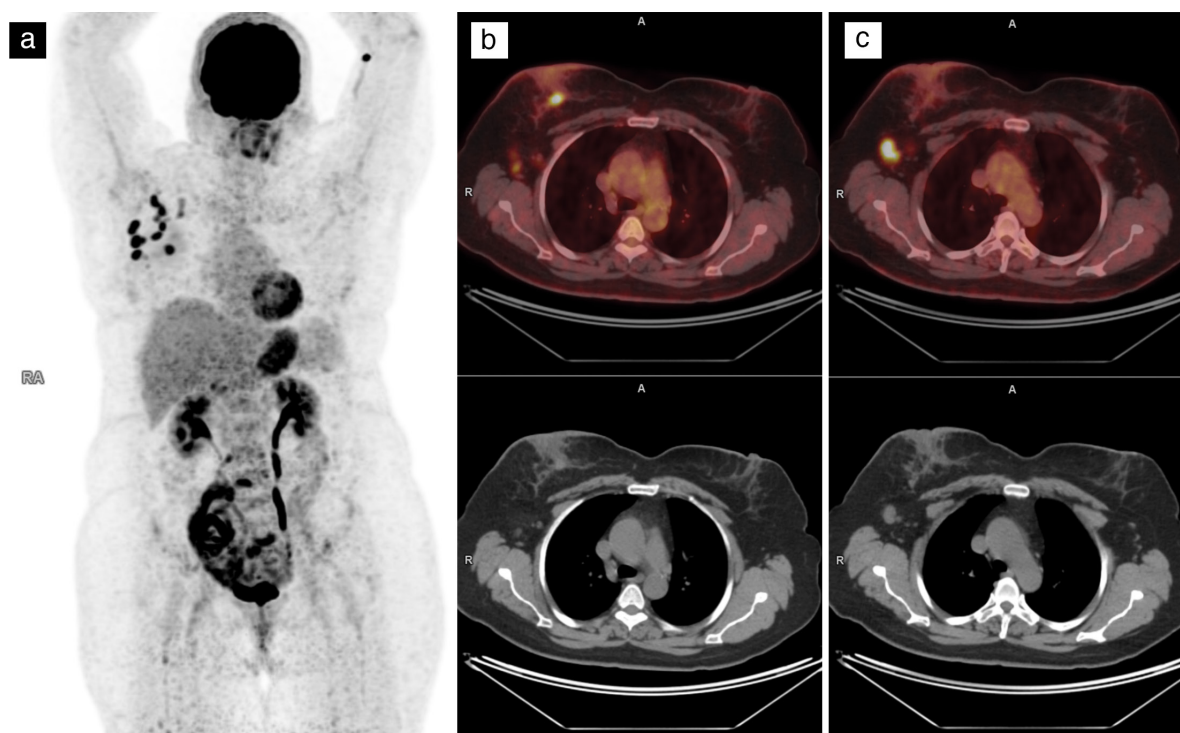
Invasive ductal carcinoma in a 49-year-old woman. (a) Maximum intensity projection positron emission tomography (PET) image demonstrates invasive ductal carcinoma in the right breast and multiple metastases in the right axillary lymph nodes. (b) Axial fused positron emission tomography-computed tomography (PET/CT), and CT show an intensely hypermetabolic focus [maximum standardized uptake value (SUV_{max}), 9.4] in the right retroareolar region with diameter of 12 x 11 mm, corresponding to the breast tumor. (c) Axial fused PET/CT, and CT reveal a metastatic axillary lymph node with high fluorodeoxyglucose (FDG) uptake (SUV_{max} : 10.7)
